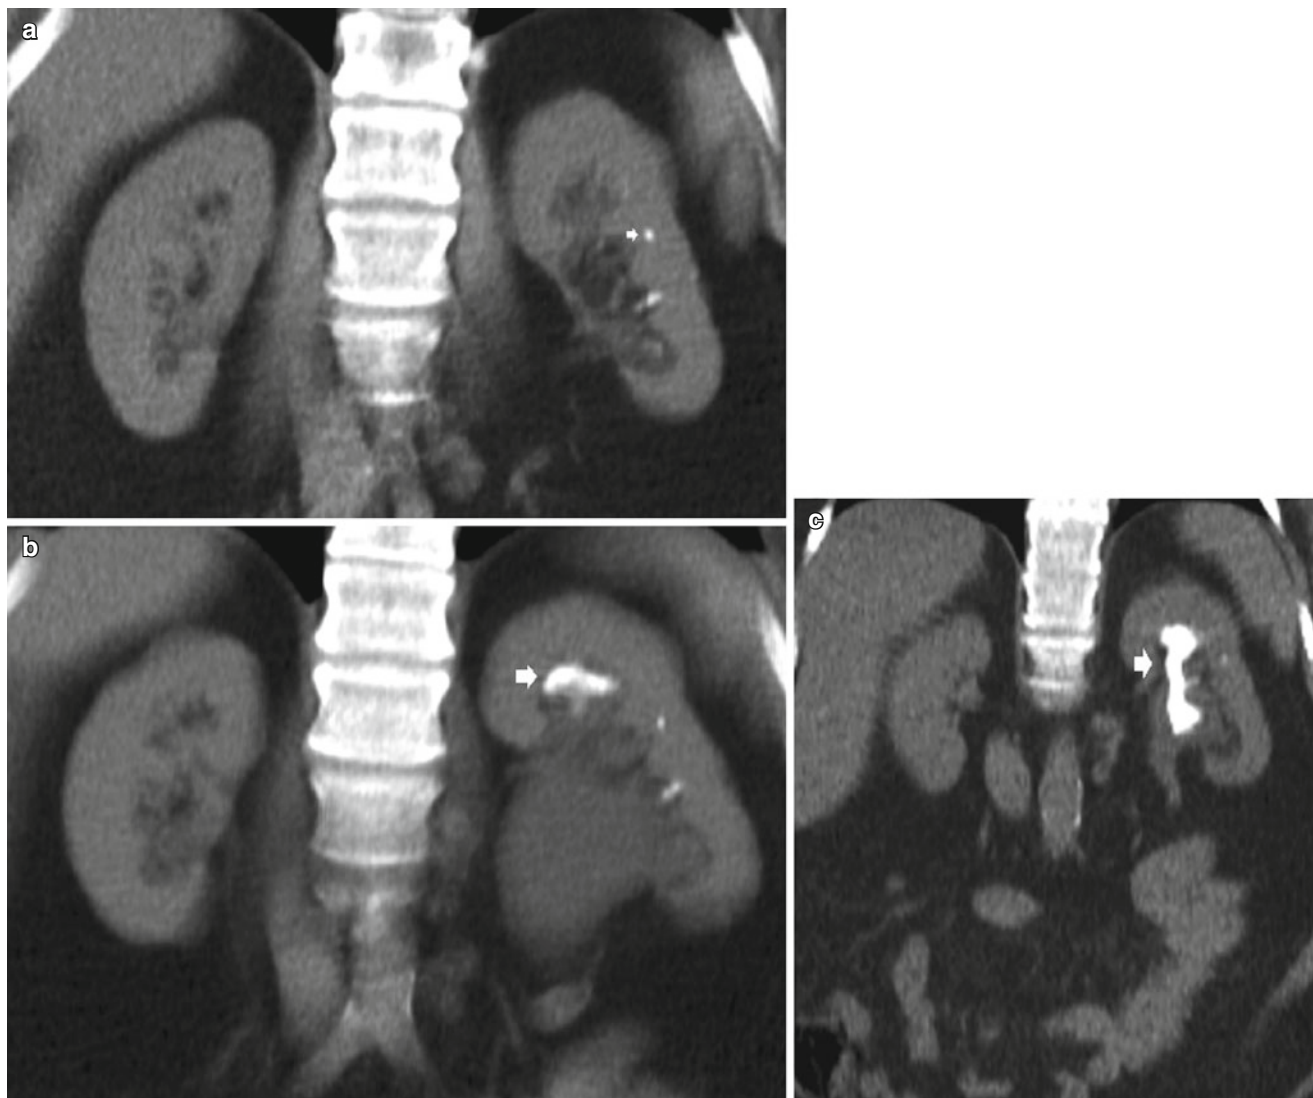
A series of unenhanced CT coronal acquired over an 18-month period demonstrating initially a calculus (arrow) in the ureter causing hydronephrosis (a), then the progressive development of a staghorn calculus (arrows) (b–c)
